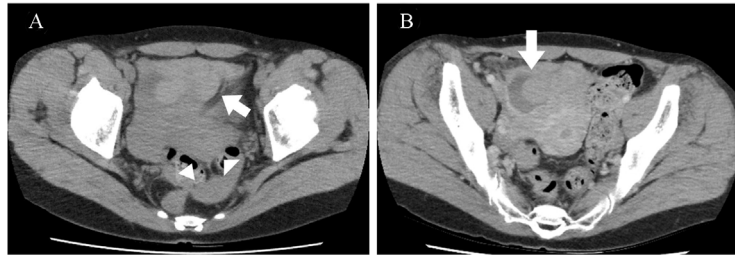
(A) Noncontrast CT shows a high attenuated area which are considered to be hematoma and hemorrhagic ascites (arrow) which was ventrally-adjacent to the uterus (arrowhead). (B) Contrast CT taken an hour later shows area with no enhancement in the mass (arrow) which corresponds to the cystic lesion found with ultrasound. CT, computed tomography.
